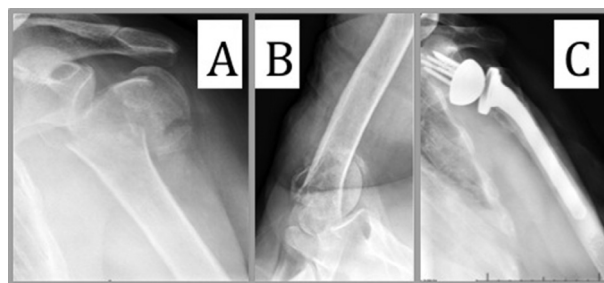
Acute proximal humerus fracture treated with a reverse total shoulder arthroplasty. (A) Anteroposterior shoulder radiograph preoperatively. (B) Axillary shoulder radiograph preoperatively. (C) Anteroposterior shoulder radiograph postoperatively.
